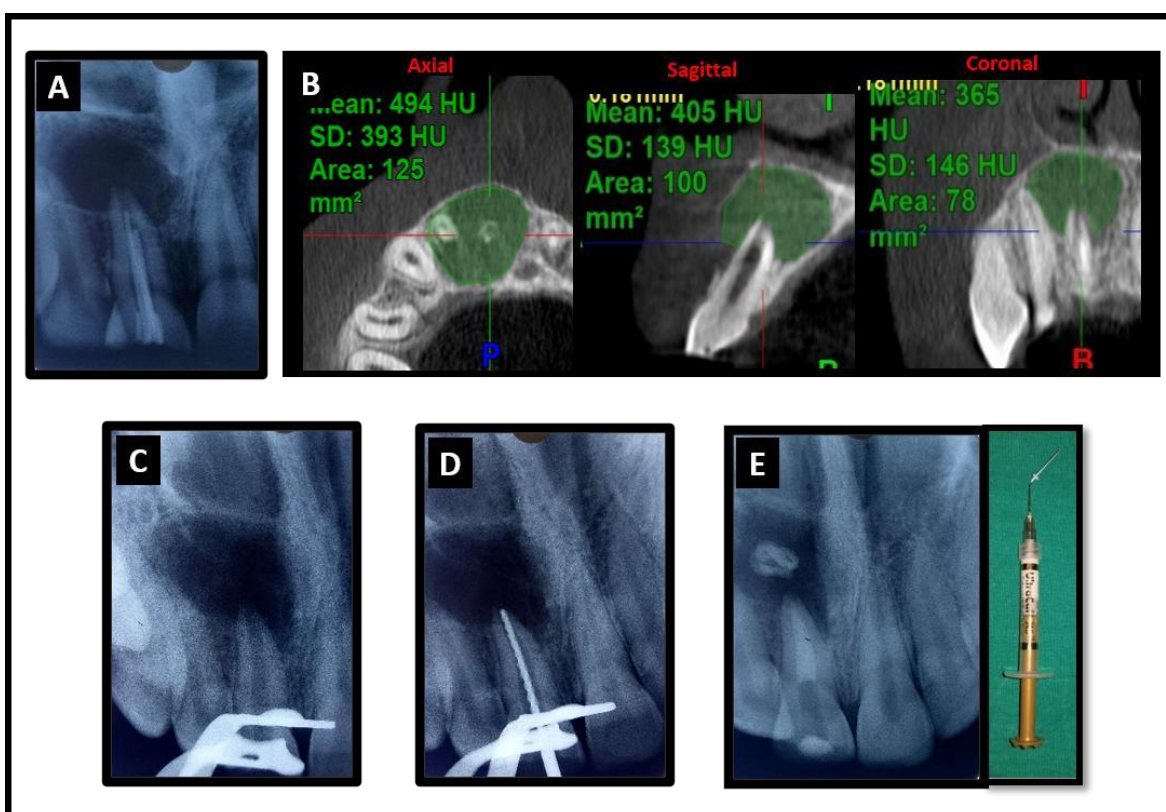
A. Pre-op IOPAR showing poorly obturated 11 along with periapical pathology B. Pre- op CBCT- Axial, Sagittal & Coronal view C.GP removed D.WL estimation E. Calcium hydroxide placed inside the canal (erroneously some amount has been pushed beyond apex)
